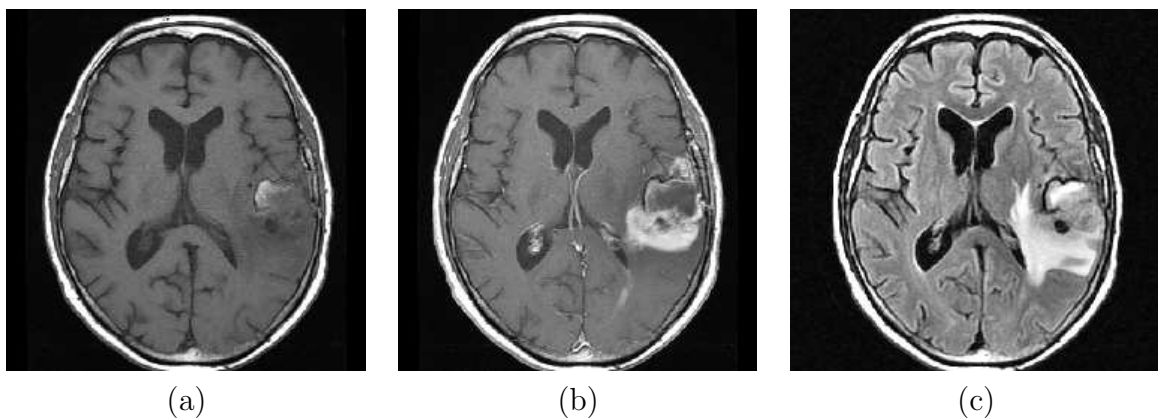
A ring-enhanced tumor. a) Axial slice of T1-weighted image. b) The same slice of contrast enhanced T1-weighted image. c) FLAIR image
